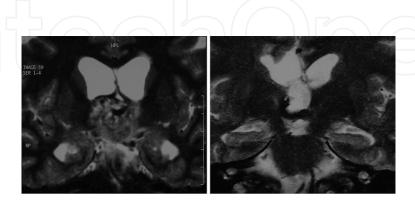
left, coronal T2W image shows a mass with heterogeneous signal intensity in the third ventricle and dilated temporal horns of the lateral ventricles. The lesion includes tubular signal void areas. Right, early postoperative MRI after right transcallosal approach.
